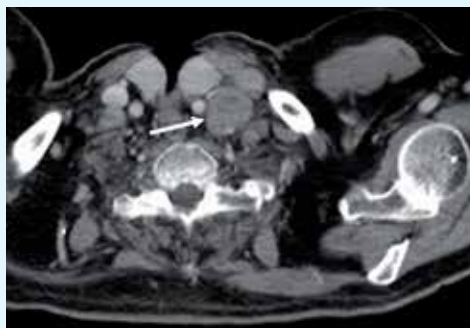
Axial CT Scan slice just above the sternal notch shows a left supraclavicular enlarged lymph node (arrow). This was biopsy proven metastatic cervical cancer. This is consistent with a stage IVB cancer.
